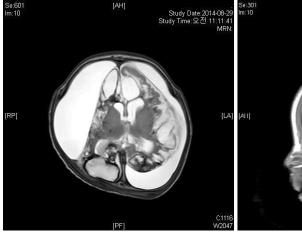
Brain magnetic resonance imaging was done at 42 day of age; we found a large bilateral subdural hemorrhage, a subacute intracranial hemorrhage in the right parietal lobe, and suspected thrombi in the straight and bilateral transverse sinuses.
